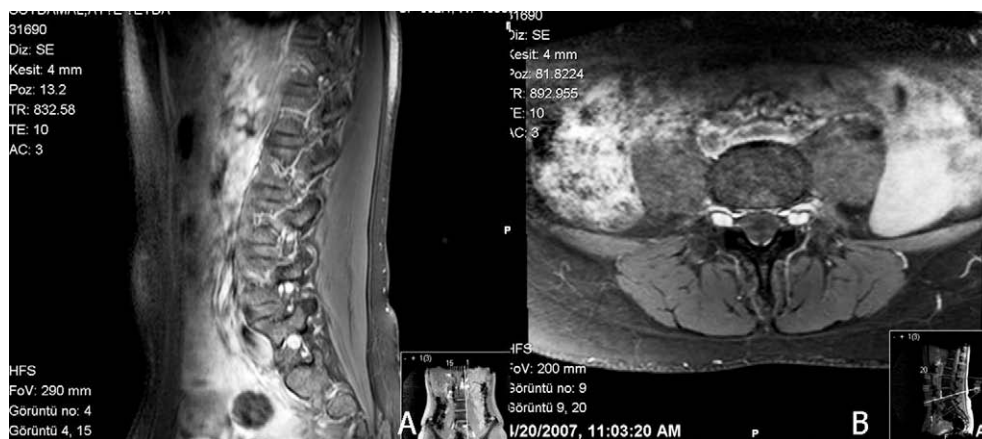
(A) Sagittal postcontrast T1-weighted lumbar MRI, and (B) axial fat-saturated T1-weighted lumbar MRI showing multiple schwannomatosis.
